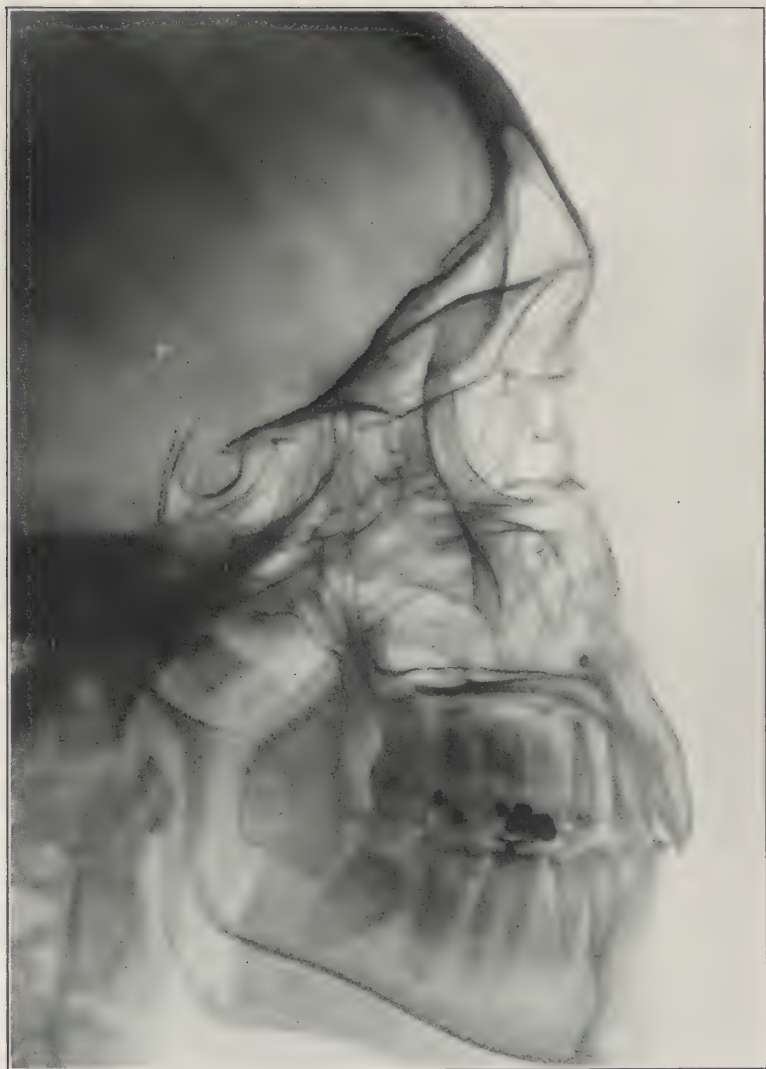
A side view X-ray plate of the case of Mr. S., showing the rare orbito-frontal cells and also large frontal sinuses.
